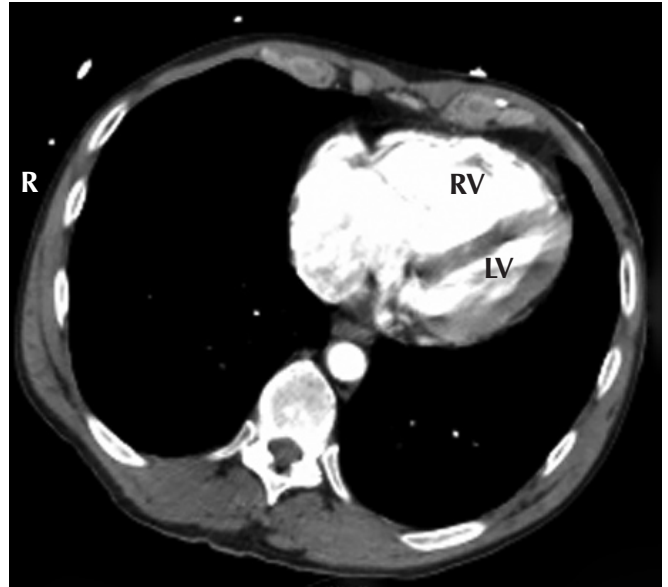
Axial computed tomographic pulmonary angiogram showing severe dilation of the right ventricle (RV). Measurement of the RV at the level of the tricuspid valve compared to the measurement of the left ventricle (LV) at the level of the mitral valve gives a RV:LV ratio of 3.
